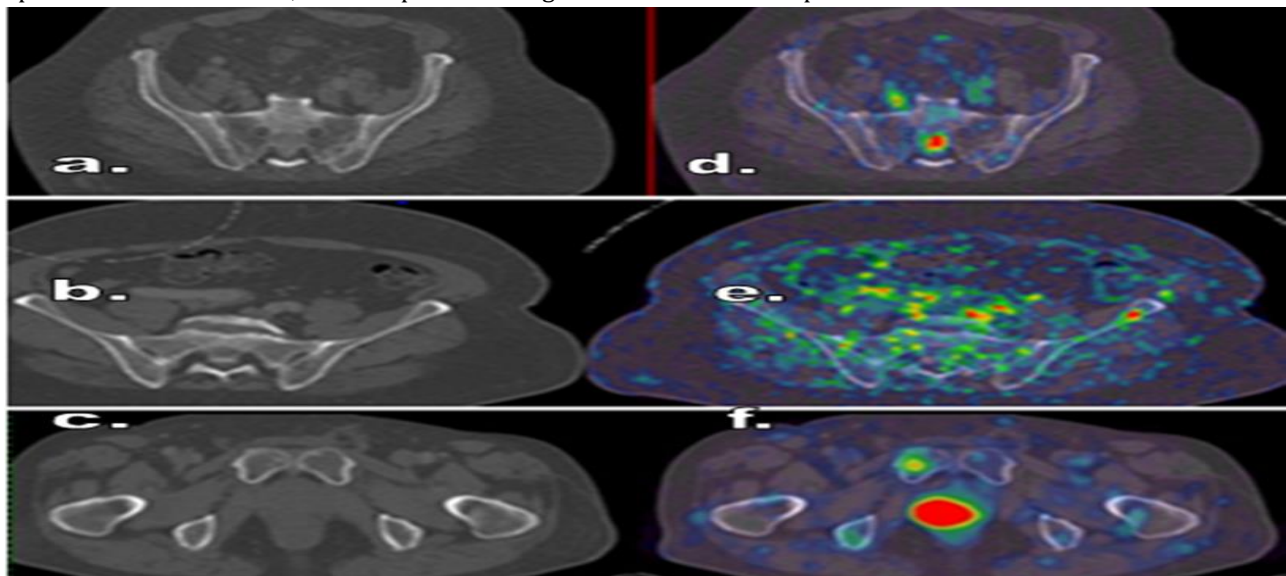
(a, b, c) axial conventional CT bone window of three different cancer prostate patients show no osseous abnormality (d, e & f) show osseous deposits in sacrum (SUVmax 20.3), left iliac bone (SUVmax 4.9), right pubic bone (SUVmax 3.1).
